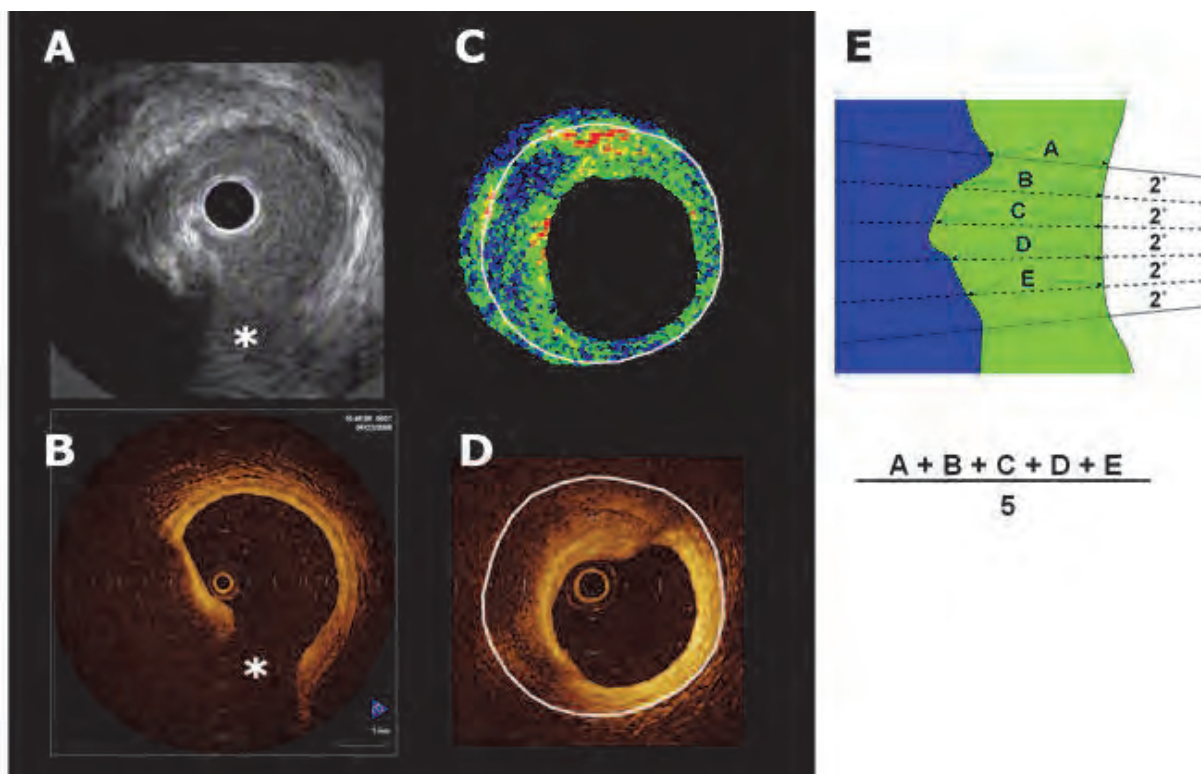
The same coronary segments were selected for imaging using the distance from easily-identifiable side branches and calcification as reference markers to ensure that integrated backscatter intravascular ultrasound (IB-IVUS) and optical coherence tomography (OCT) were compared at the same site. (A) Conventional IVUS image. (B) Corresponding OCT image. (C) IB-IVUS image. (D) Corresponding OCT image. (E) Fibrous caps that overlaid lipid pool were divided into regions-of-interest (ROIs) (every 10° from the center of the vessel) and the thickness of fibrous caps was measured as an average. The average thickness of fibrous cap was measured by averaging the thickness of fibrous cap every 2° within ROIs. \*: septal branch.
